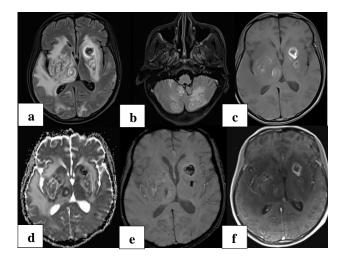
20-year HIV positive male with severely reduced CD4 count (10 cells/microlitre); (a) and (b) imaging revealed concentric hyper and hypointensity lesions on FLAIR images in bilateral basal ganglia, right thalamus and bilateral cerebellar hemispheres; (c), (d), and (e) the lesions were hypo-isointense on T1 with a hyperintense rim that showed blooming and restriction s/o hemorrhagic areas; and (f) there was ring enhancement of lesions with eccentric target sign.
